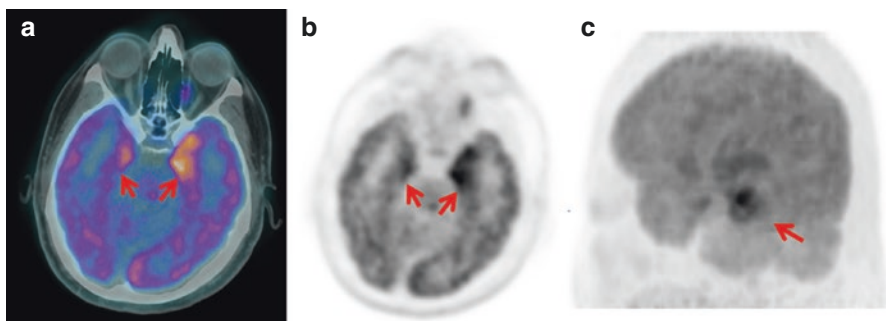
(a–c) Axial fused ^{18}F FDG PET/CT (a), axial ^{18}F FDG PET (b) and 3D MIP (c) in a patient with worsening left arm, leg weakness and ataxia show increased tracer uptake in the medial temporal lobes, much more marked on the left side (a–c, arrows). These appearances can be seen in limbic encephalitis.
